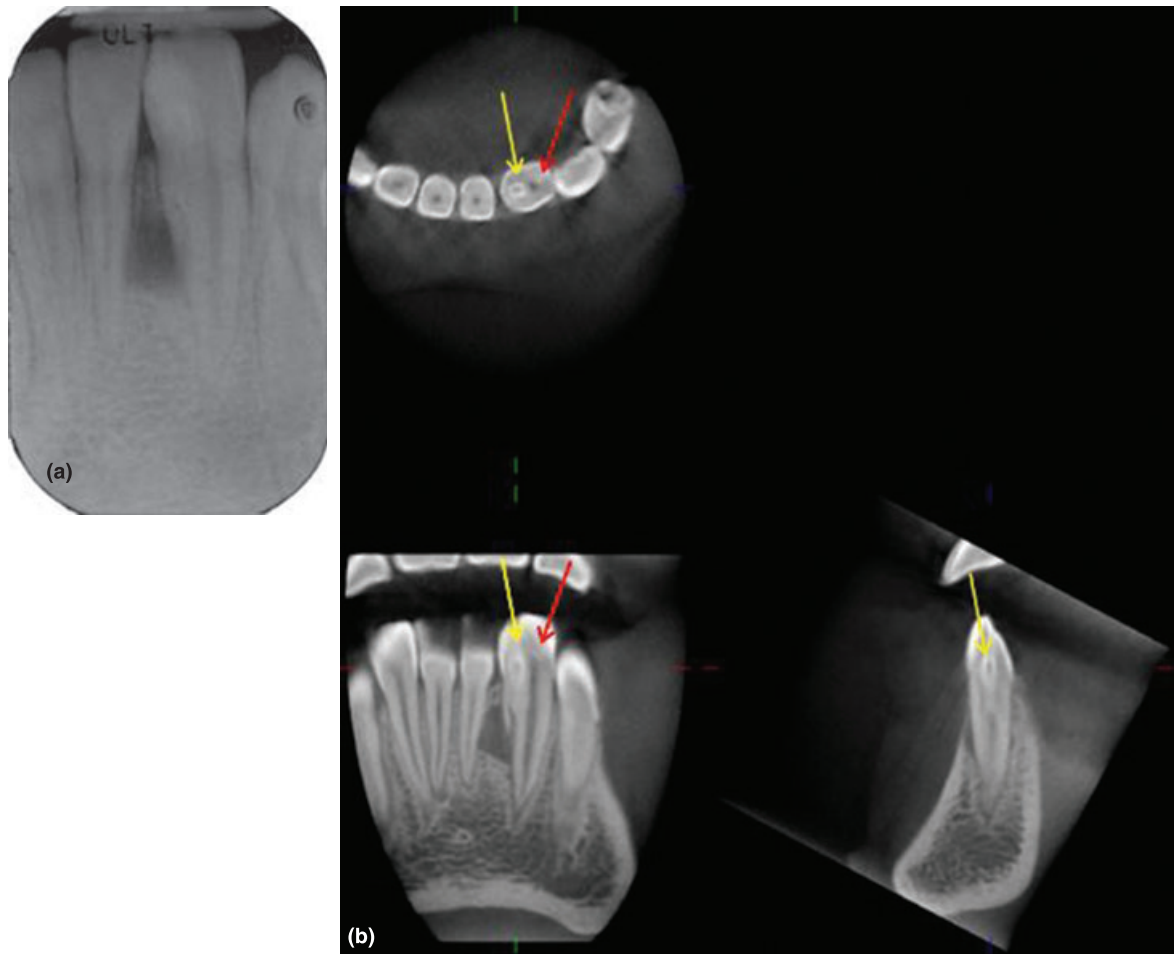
(a) An invaginated lower left second incisor tooth with an associated periapical radiolucency. (b) Only with cone beam computed tomography scans can the relationship of the invagination (yellow arrow) and the root canal (red arrow) be assessed, from this data it is also possible to confirm that the periapical radiolucency is associated with the invagination only.
